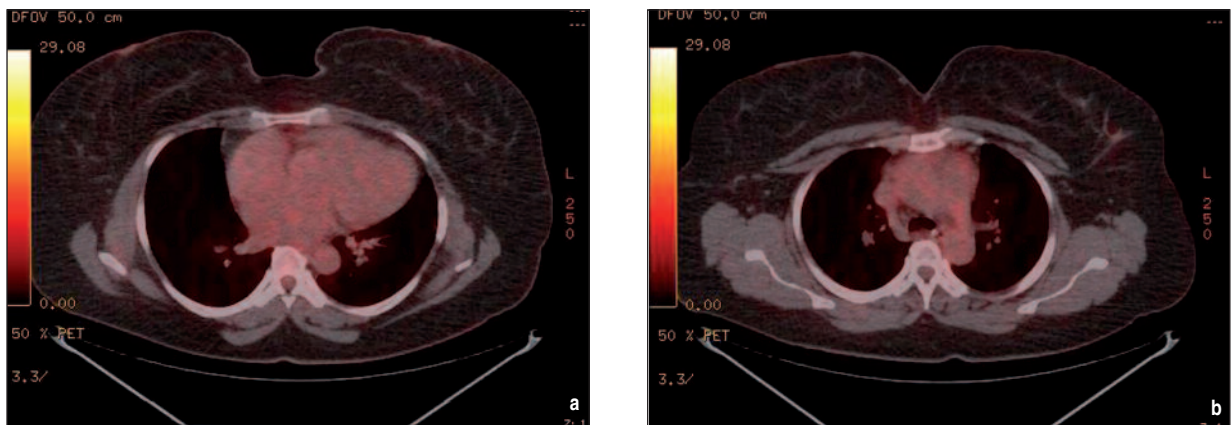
PET-CT scan of the patient that shows no 18F-FDG uptake on mediastinal level.
